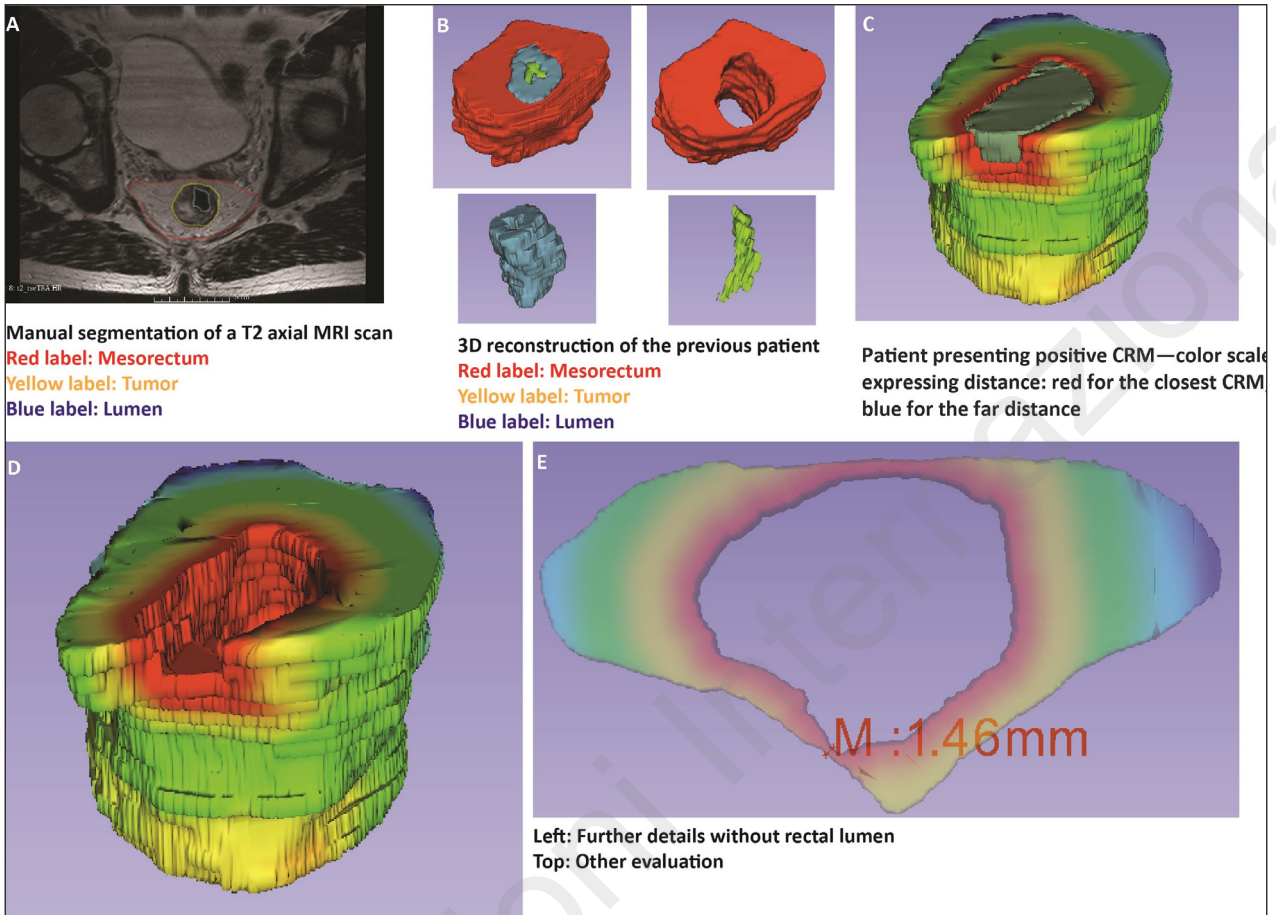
Results of the 3D MRI imaging segmentation plus application of the color scale: A) Manual segmentation; B) 3D reconstruction of different structures; C) 3D volumes plus color scale; D) 3D mesorectal volume with color scale; E) Example of CRM calculation on the closest red distance.
